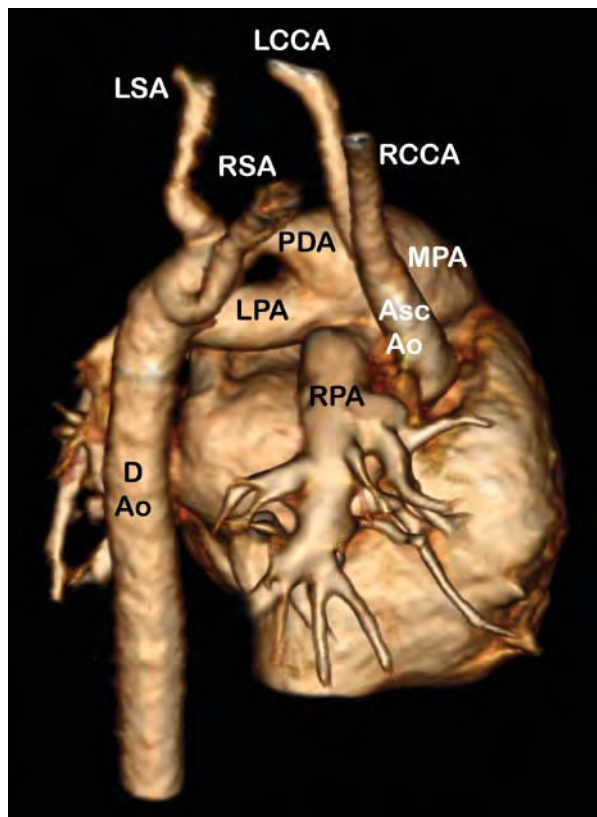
Computed tomographic 3D reconstruction (posterior view) of type B interrupted aortic arch with aberrant right subclavian artery.
